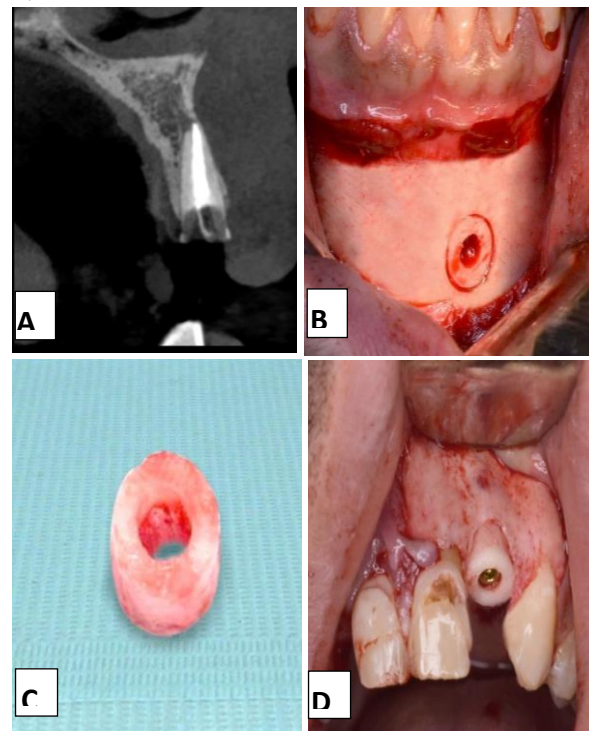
CBCT Preoperative Cross-sectional view (A). Osteotomy site preparation through bone ring (B). Fresh autogenous bone ring from chin area. (C). Implant with autogenous bone ring placement (D)
